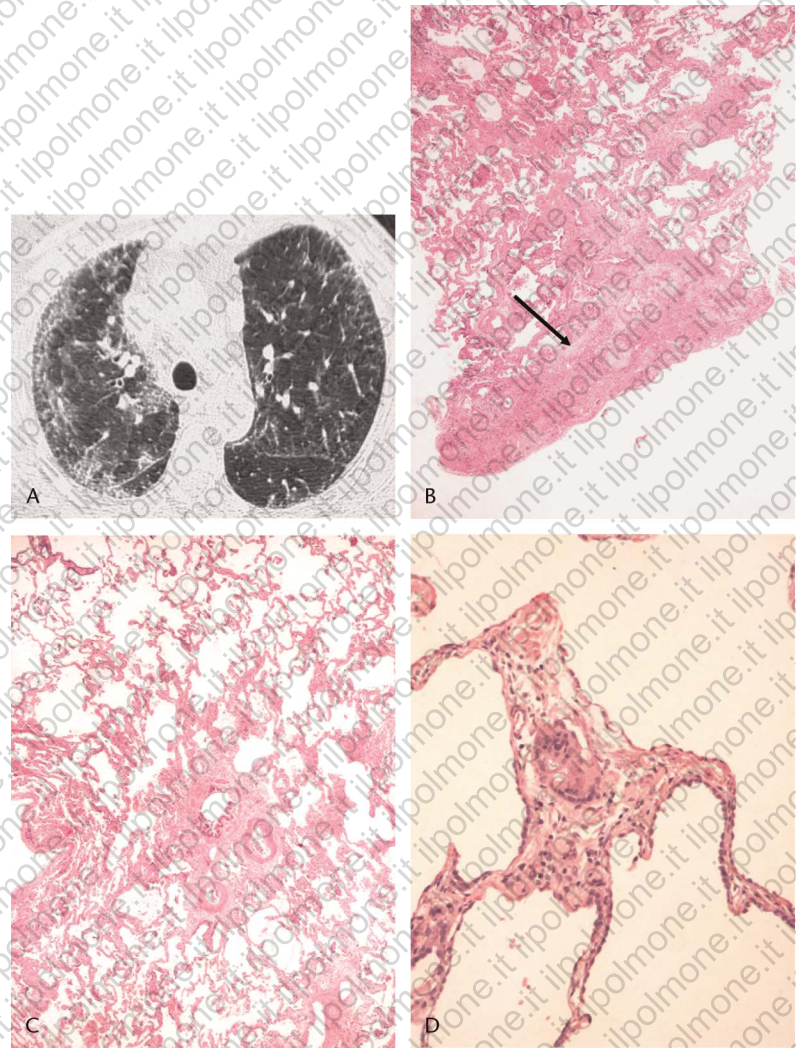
Chronic HP in a patient with unknown exposure (case no. 13). A, High-resolution CT scan images show bilateral reticular pattern and focal ground glass opacities. The appearance resembles that of UIP. B, Lower power view showing irregular peripheral fibrosis with architectural distortion and a fibroblast focus (arrow). C, Another area demonstrating peribronchiolar fibrosis extending into surrounding alveolar walls. The airway wall itself is fibrotic, suggesting an old inflammatory process. D, Higher power view of another field showing an interstitial giant cell. $\alpha+$
